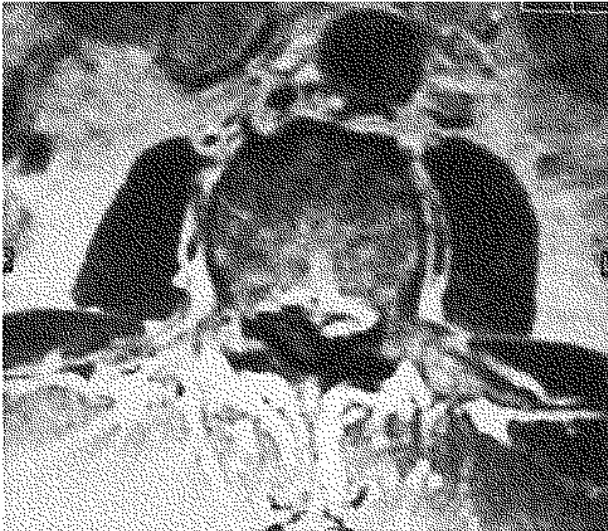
Axial MRI T1-weighted image (1,5 Tesla, Tr = 460 msec, Te = 20 msec), showing the lateral L3-L4 herniation. The image is the same as that in fig. 3; left and right are inverted for technical reasons.
